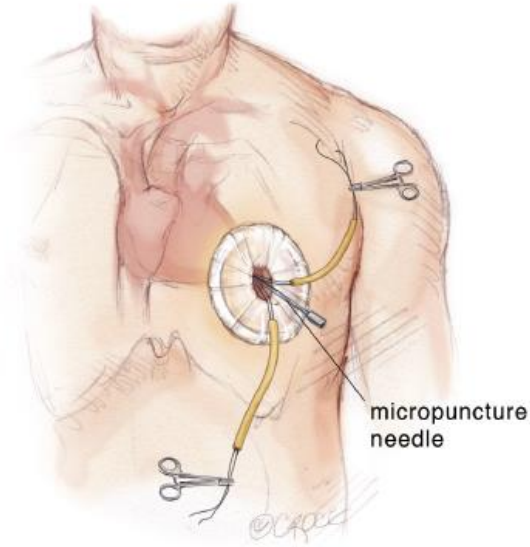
A micropuncture needle is used to gain entry into the left ventricular (LV) cavity with the needle directed toward the right shoulder. Transesophageal echocardiography (TEE) is used to confirm positioning of the needle in the LV apex.
